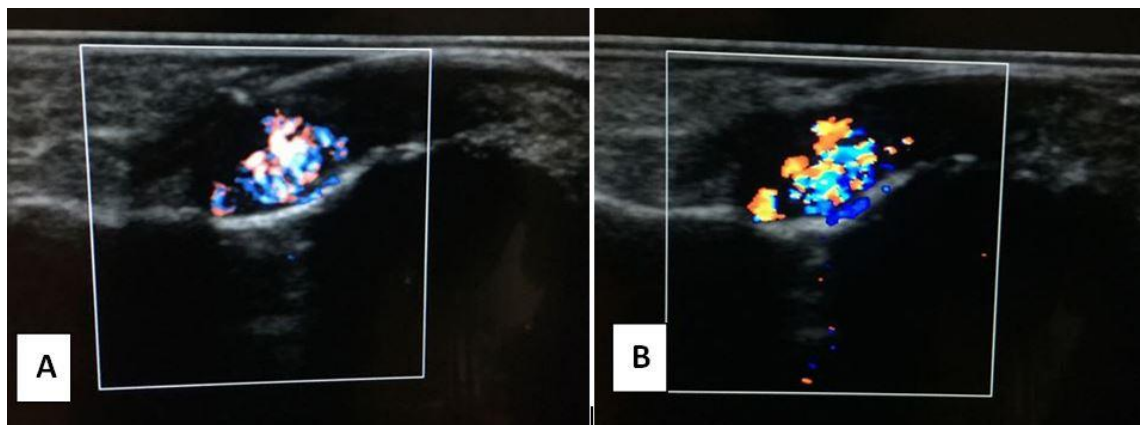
A) There is a well defined hypoechoic lesion (3.0 × 2.0 mm) under nailbed; B) showing hypervascularity on color Doppler USG.
